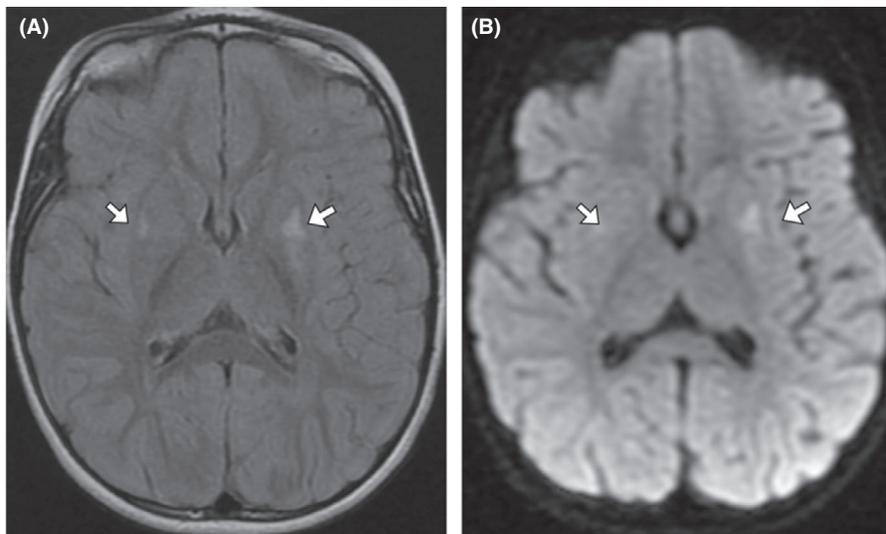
MRI of the Brain at 34 months of age. (A) Axial T2 imaging demonstrating new areas of edema within the putamen nuclei (arrows). (B) Corresponding axial Diffusion Weighted images demonstrating cytotoxic edema in the bilateral putamen nuclei (arrows)
